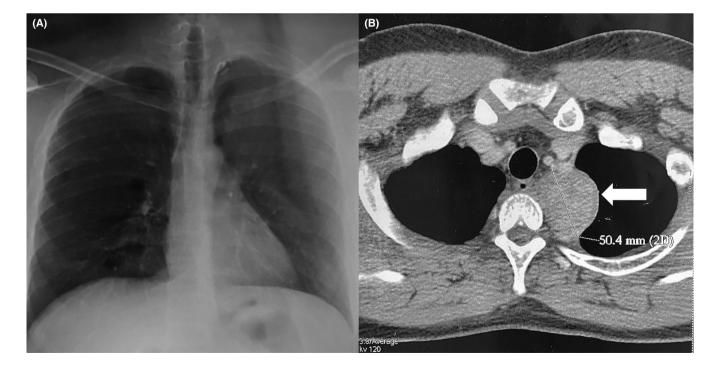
(A) Chest radiography showing no sign of tumor. (B) Computed tomography of the thorax showing a 50×54mm left laterovertebral mediastinal mass (arrow) with an heterogeneous density without calcified or fatty cystic component in contact with the left subclavian artery without signs of invasion.
